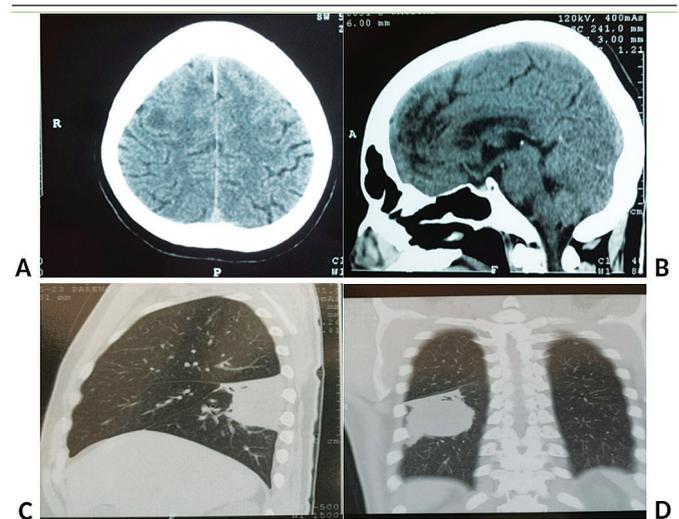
A and B) CT of the skull detected small areas of undetermined hypodensity, distributed in the subcortical and white matter of both cerebral hemispheres; C and D) CT of thorax showed a lobar parenchymal consolidation of the right lower lobe, with permeable air bronchograms and small non-calcified pulmonary nodules
